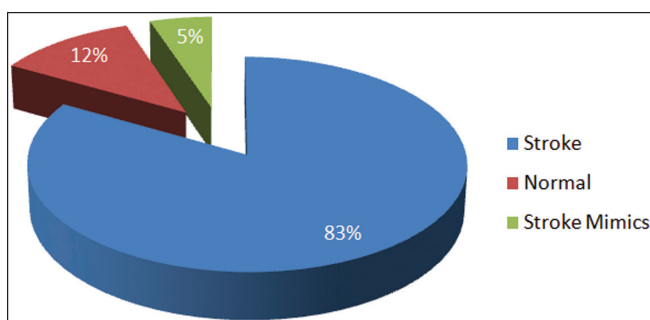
Pie chart showing the number of subjects with normal and abnormal CT findings (stroke and stroke mimics)
